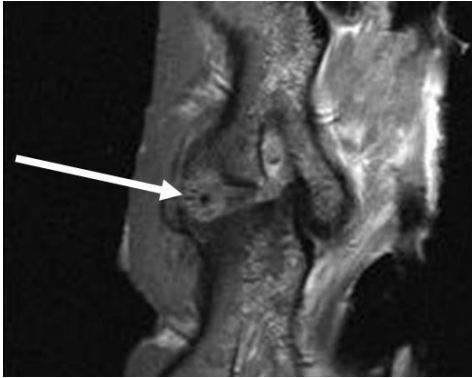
MRI image that shows that the annulus closure system is located in the centre of the endplate reaction (arrow), suggesting a causative role.
